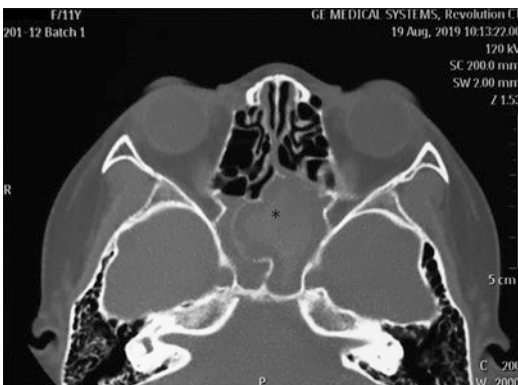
Axial paranasal sinus computed tomography (CT) image in an 11-year-old girl with chronic sphenoid sinusitis. She experienced an intermittent severe headache for 6 months but no nasal symptoms, and she experienced no improvement after medical treatment. CT demonstrated opacification in bilateral sphenoid sinuses
